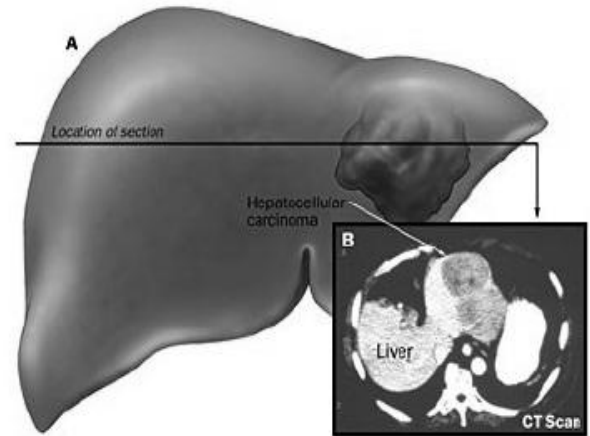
A-Hepatocellular carcinoma in healthy liver; B- corresponding computed tomography (CT) scan.
